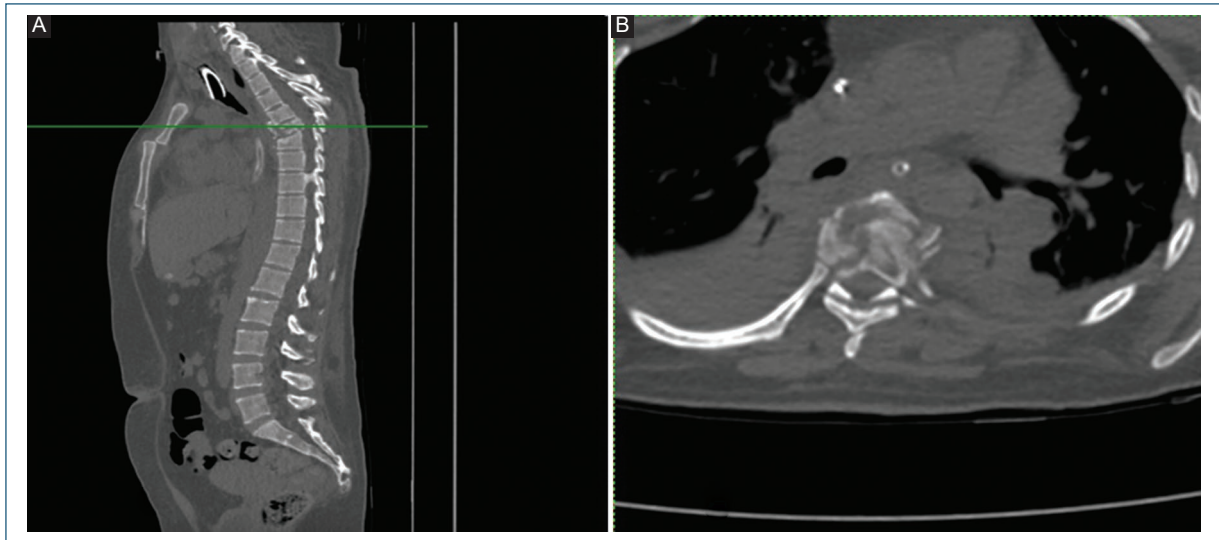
A: simple sagittal computed tomography (CT) view of the spine showing a fracture-dislocation at T6-T7 level and a sternal manubrium fracture that required conservative management. B: axial CT showing a fracture of all 3 Denis columns at T6 level.
